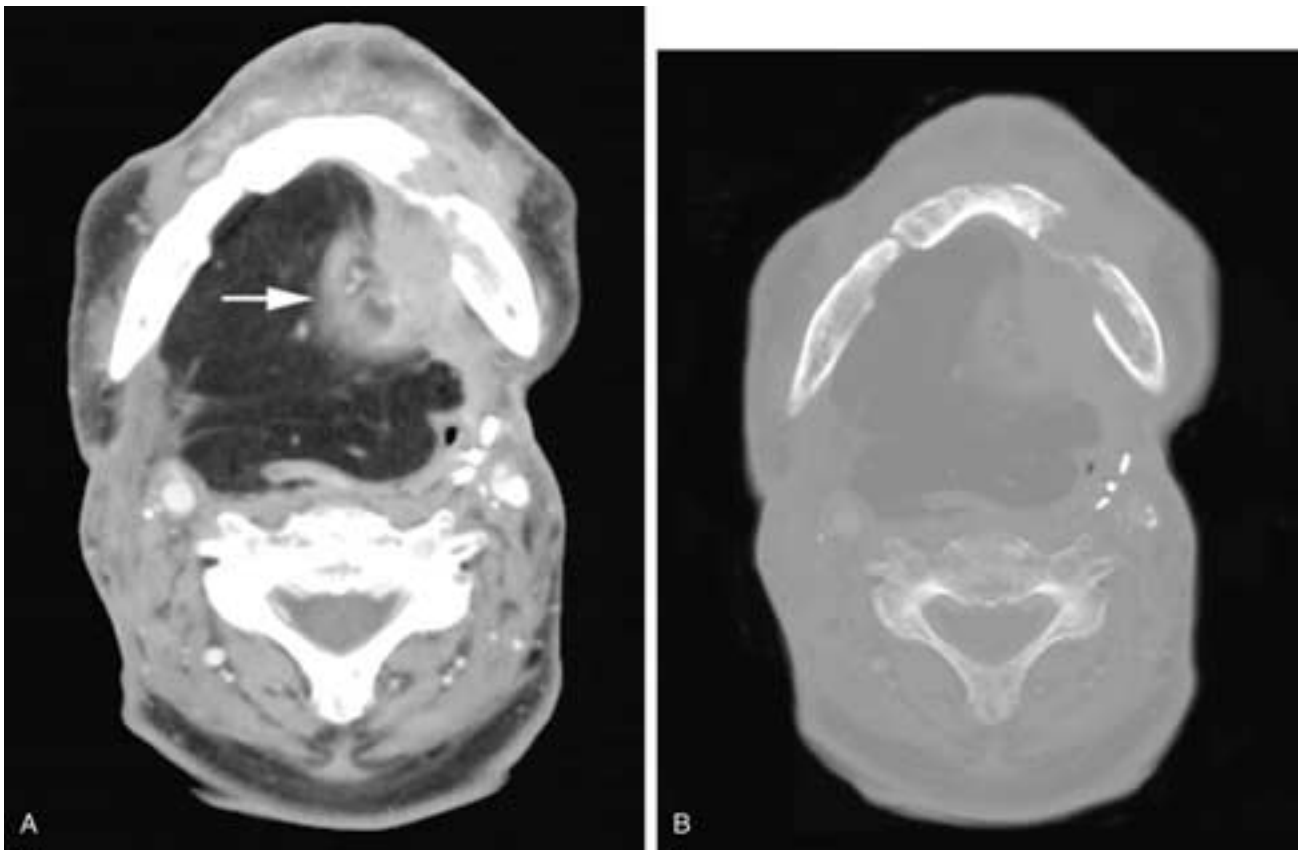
Axial contrast-enhanced CT scan on a patient who has had a total glossectomy and partial mandibulectomy with osteomyocutaneous flap reconstruction and bilateral neck dissections. In A, note the soft-tissue nodular recurrence (*arrow*) within the left side of the flap and the infiltrating extension into the mandible. In B, the destruction of both the native left mandible and the back of the left side of the transplanted bone is better seen.
